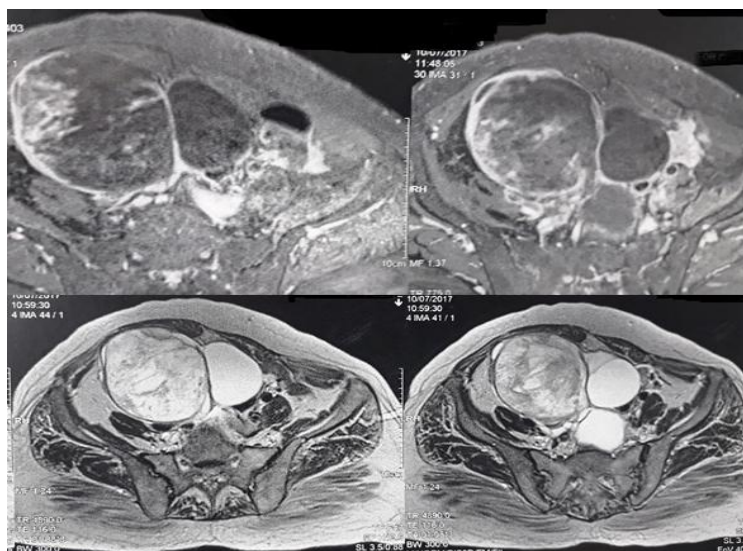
CT scan of the abdominopelvic mass measuring 17x12 cm
